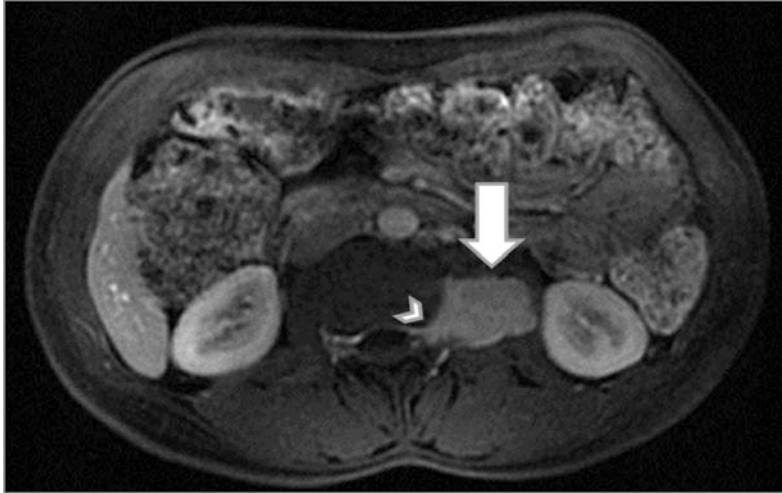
T1-weighted fat-suppressed axial image, acquired after administration of Gadolinium, in a patient with left lumbar pain and paraesthesia. The study revealed a bulky left paravertebral mass with diffuse
